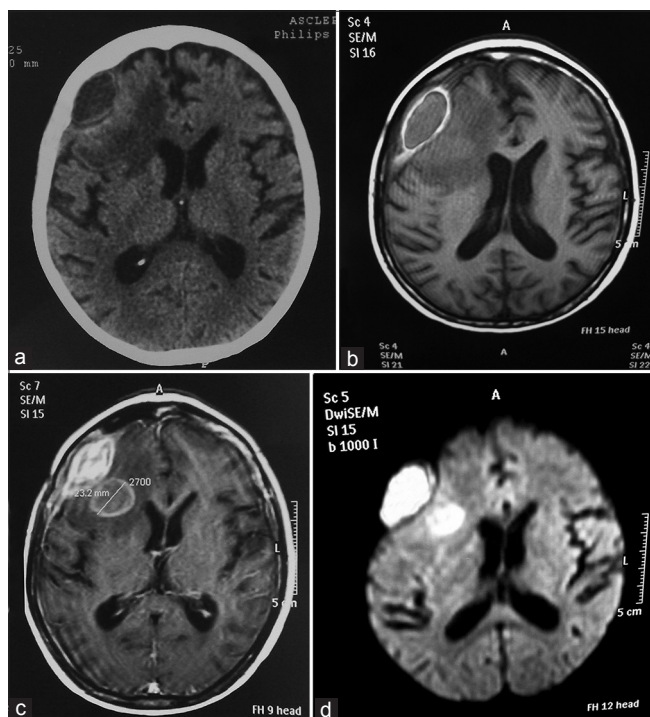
(a) Brain computed tomography scan without contrast, and (b) T1 – weighted postcontrast image reveals a hyperdense to cerebrospinal fluid right frontal subdural collection with clear capsule formation, and an adjacent intraparenchymal lesion of low signal with considerable edema. (c) Fluid-attenuated inversion recovery postcontrast sequence demonstrates a densely enhancing extraaxial lesion and a well-defined ring enhancing brain lesion. (d) On diffusion-weighted image, the core of the subdural and brain lesion has typically markedly hyperintense signal (restricted diffusion)
